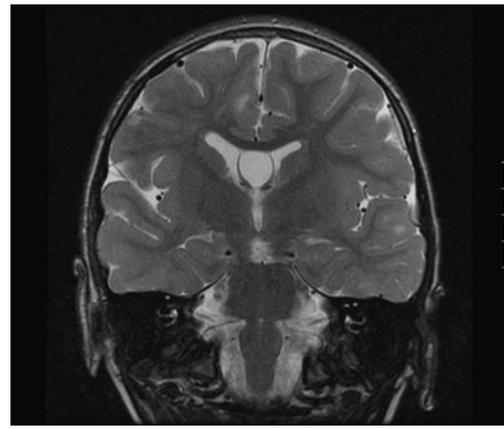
Axial MRI noting a cavum velum interpositum
